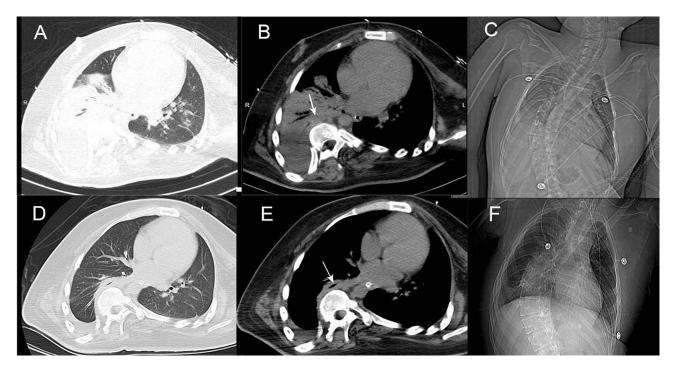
Chest imaging before and after treatment. (A) Lung window: Pre-treatment computed tomography (CT) scan showing right lower lobe consolidation with air bronchogram; (B) Mediastinal window: white arrow indicating right inferior lobar bronchus compressed by curved spine in pre-treatment CT. (C) X-ray positioning film showing right lower lobe high density shadow with right costophrenic angle disappeared. (D) Lung window: Follow-up CT scan after antifungal treatment for 14 days showing right lower lobe consolidation absorbed and a small amount exudates in the right thoracic cavity. (E) Mediastinal window: white arrow indicating right inferior lobar bronchus still compressed by curved spine in follow-up CT. (F) Follow-up X-ray positioning film showing increased opacity of right lower lobe with right costophrenic angle appeared.
